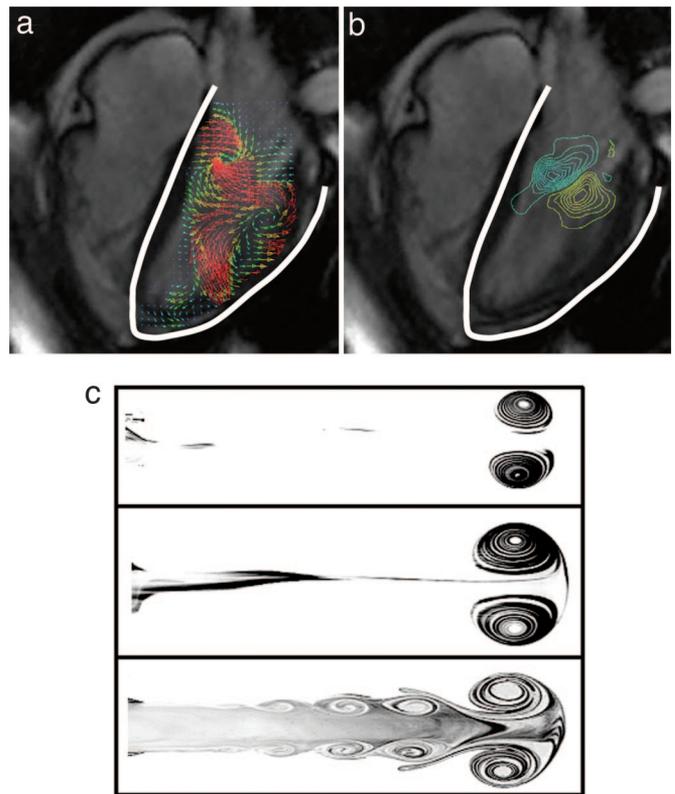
Vortex ring formation *in vivo* and *in vitro*. (*a* and *b*) Map of *in vivo* blood flow velocity vectors and vorticity (rotation and shear) contours in the LV of a human heart during diastole. Images were obtained by magnetic resonance imaging of a healthy adult (courtesy of the Vascular Imaging Research Center, Department of Radiology, Veterans Affairs Medical Center/University of California, San Francisco). For emphasis, the LV boundary is indicated by a white line. Vortical patterns are indicated by the orientation of velocity vectors and by vorticity contours. Blue and yellow contours indicate clockwise and counterclockwise fluid rotation, respectively. (*c*) Fluorescent dye images of *in vitro* vortex ring formation in fluid jets with increasing vortex formation time. (*Top*) $T = 2.0$. (*Middle*) $T = 3.8$. (*Bottom*) $T = 14.5$. For $T > 4$, vortex ring growth terminates and fluid is subsequently ejected in a trailing jet. Figure is adapted from ref. 14.
